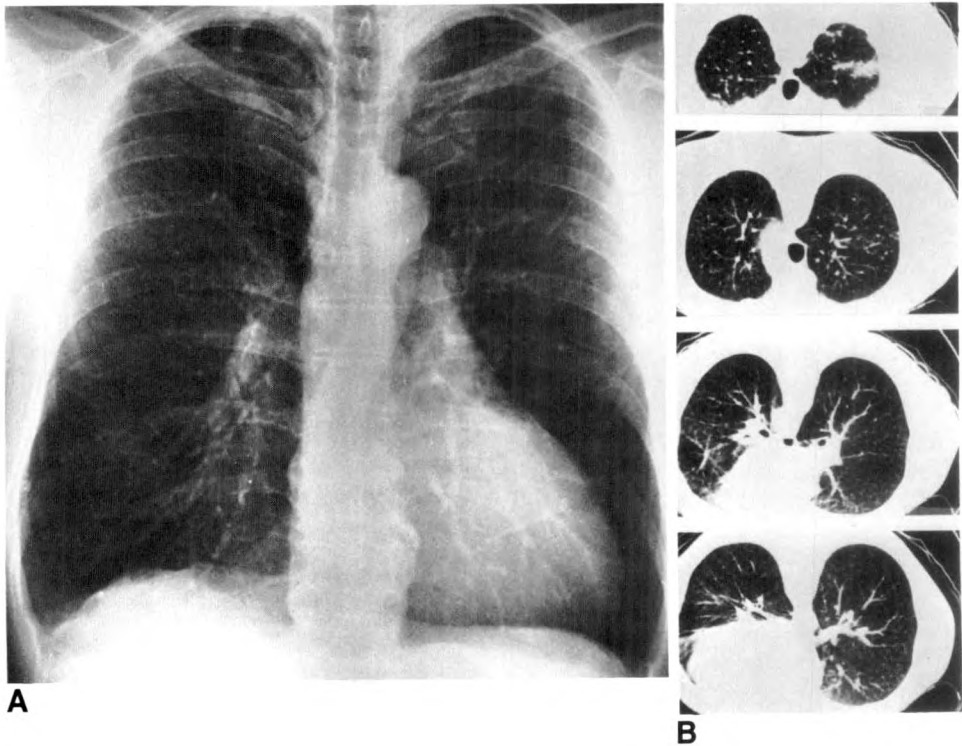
Chest radiograph (A) and CT scans (B) of patient with nodular silicosis. The abnormalities are seen equally well on chest radiograph and CT scans, but an upper-lobe conglomeration can be appreciated only on CT.
